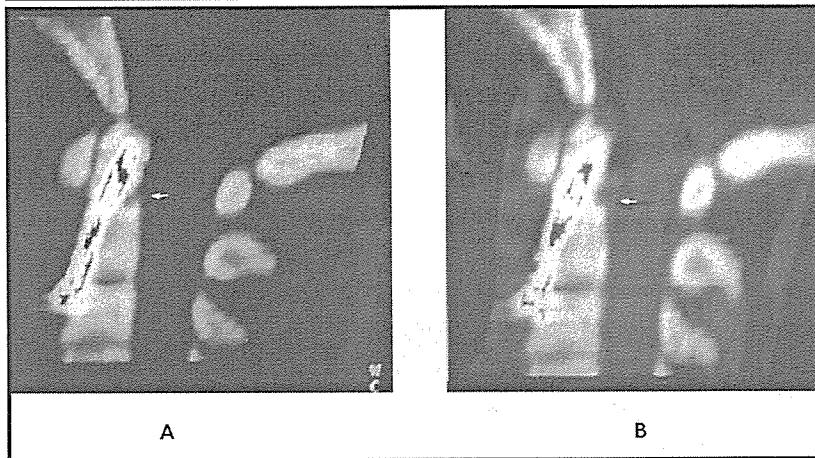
Rearthrosis of Type II odontoid fracture after surgery remarked by arrow (in sagittal CT scan).
